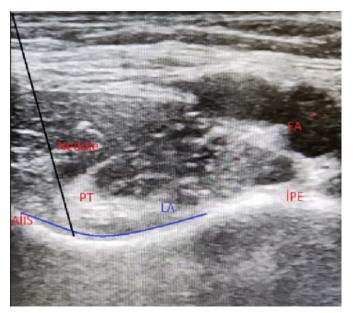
Sonographic view of PENG block. (FA: Femoral artery, PT: Psoas tendon, IPE: Ileopubic eminence, AIIS: Anterior inferior iliac spine, LA: Local anesthetic)
